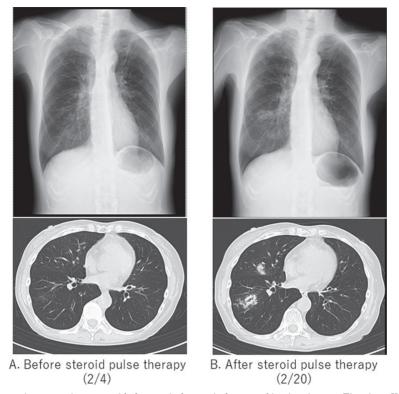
Chest X-ray and computed tomographic images before and after steroid pulse therapy. The chest X-ray revealed new opacities on both sides of the lung. The computed tomographic images revealed multiple nodular lesions with surround-ing ground-glass opacities.
